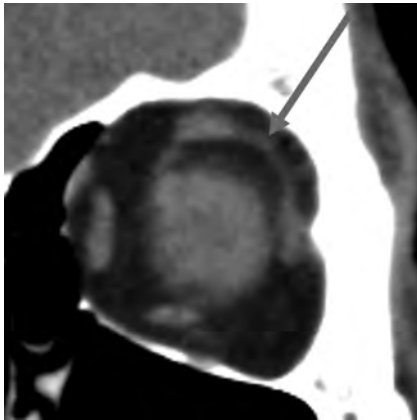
CT appearance of the LR-SR band in a 54-year-old woman. Coronal image of the left orbit demonstrates the LR-SR band (arrow).
